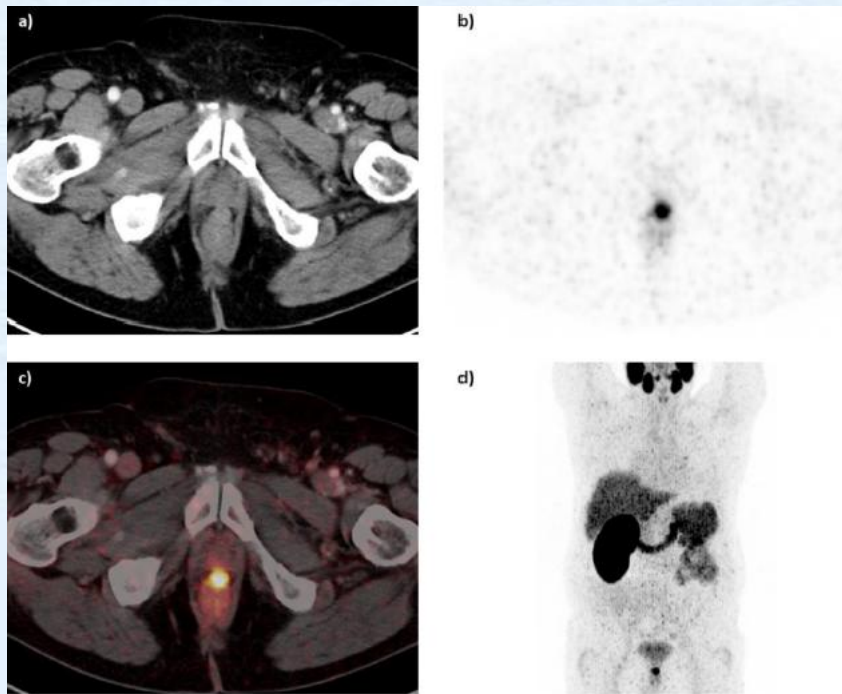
^{68}Ga -HBED-CC-PSMA PET/CT image of a patient with locally recurrent PCa (PSA 3.7 ng/ml) after radical prostatectomy (SUVmax 12.4) who received 140 MBq of the ^{68}Ga -labeled tracer molecule and was scanned at 1 h p.i.; a) CT image, b) PET image, c) PET/CT fusion image, d) MIP.
